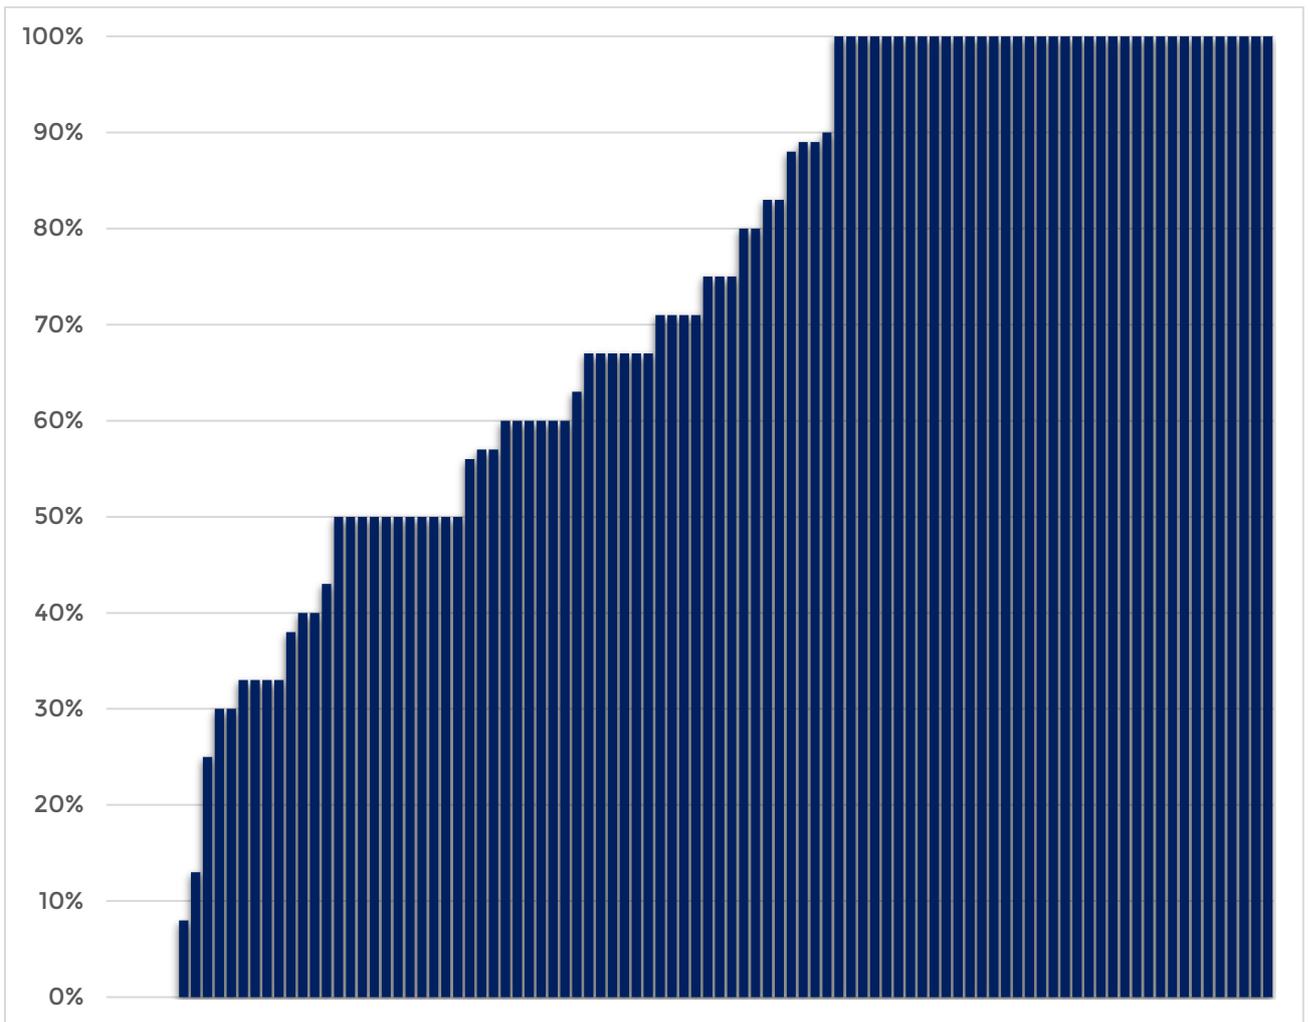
Percentage of children and young people with defined indications for an MRI, who had MRI by first year by Health Board and Trust, Round 3, cohort 1.
